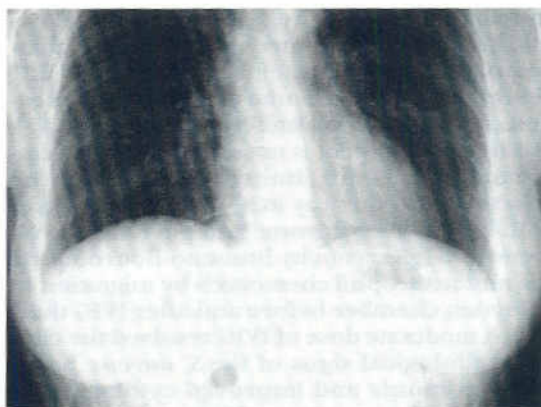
Chest X-ray after a week of treatment. Recovery.
